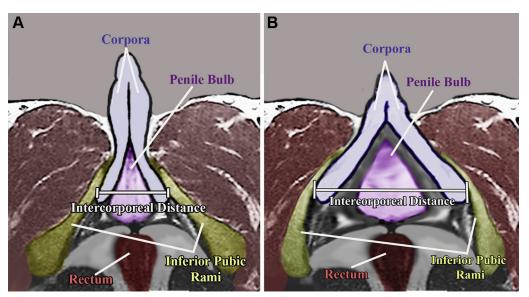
Graphic representation of an axial magnetic resonance imaging scan demonstrating differences between a normal pelvis (A) and exstrophy pelvis (B). Pertinent structures are labeled and colored-coded. Notice the increased intercorporeal distance in the exstrophy pelvis resulting from pubic diastasis.
